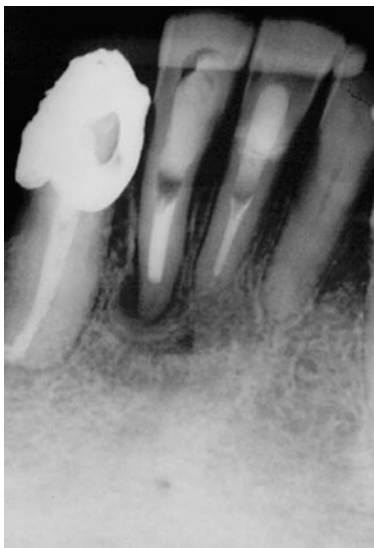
One-year follow-up with reduction of the periapical lesion size.
